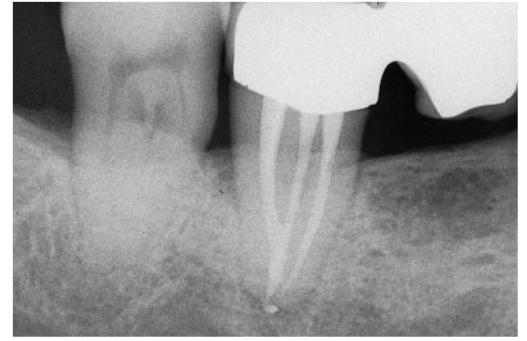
A lower second molar with two distal and two mesial root canals. The distobuccal canal flows into the mesiobuccal canal. A. Preoperative radiograph. B. Access cavity. Note that the two orifices of the buccal canals, mesial and distal, are close together. C. An instrument introduced into the distobuccal canal reveals an unsuspected confluence in the mesiobuccal canal. D. Two thin instruments placed into two canals confirm the confluence. E. Impression left on the gutta-percha cone, which had been introduced into the distobuccal canal, by a #08 file introduced in the mesiobuccal canal. F. Cone fit. G. Postoperative radiograph. H. Two year recall.
